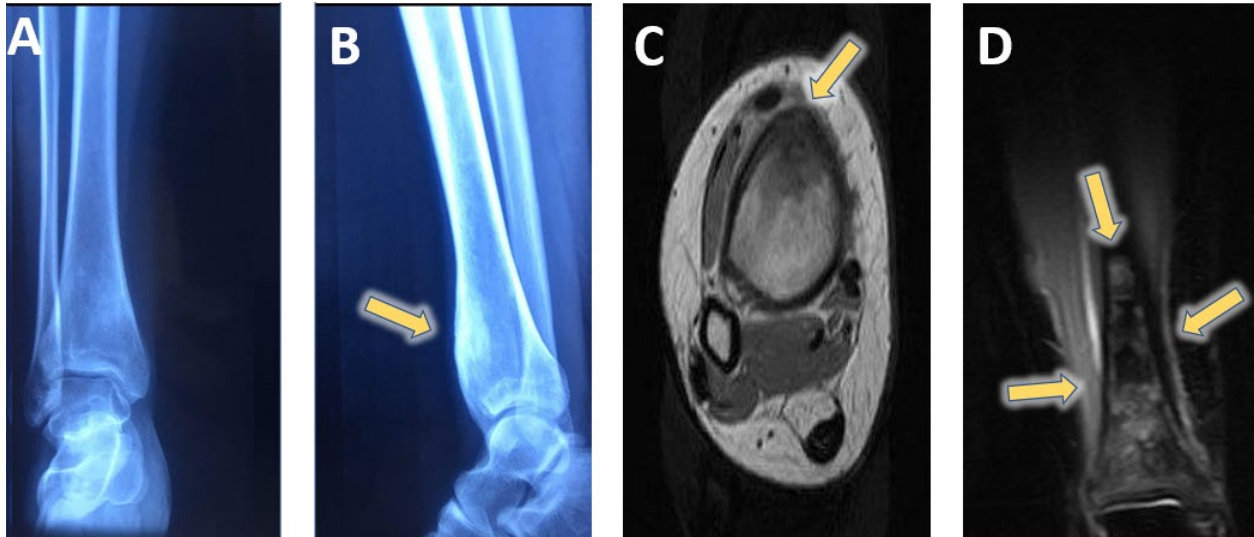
(A) Frontal and (B) lateral X-rays of the leg show focal solid cortical thickening with sclerosis involving the distal anterior medial tibial metaphysis (yellow arrows). Figure 1. (C) Magnetic resonance imaging axial T1, (D) STIR showing small subcortical rounded T1 and T2 hypointense lesion, posterior to hypointense cortical thickening, and surrounded by bone marrow edema (yellow arrows).
